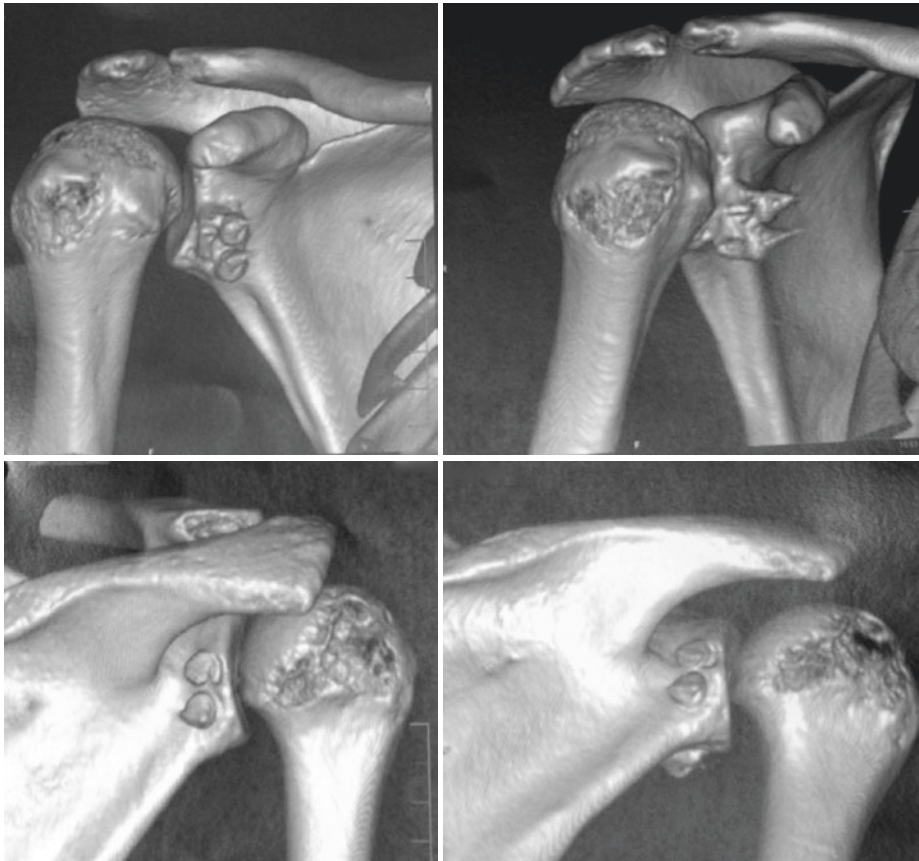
Postoperative 3D CT scan reconstruction at 1-year follow-up showing consolidated graft to the glenoid in acceptable position
